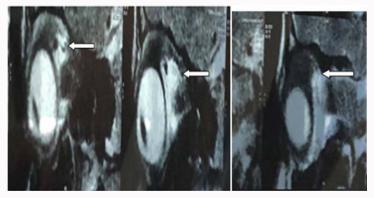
Computed tomography scan of the orbit showing secondaries.
